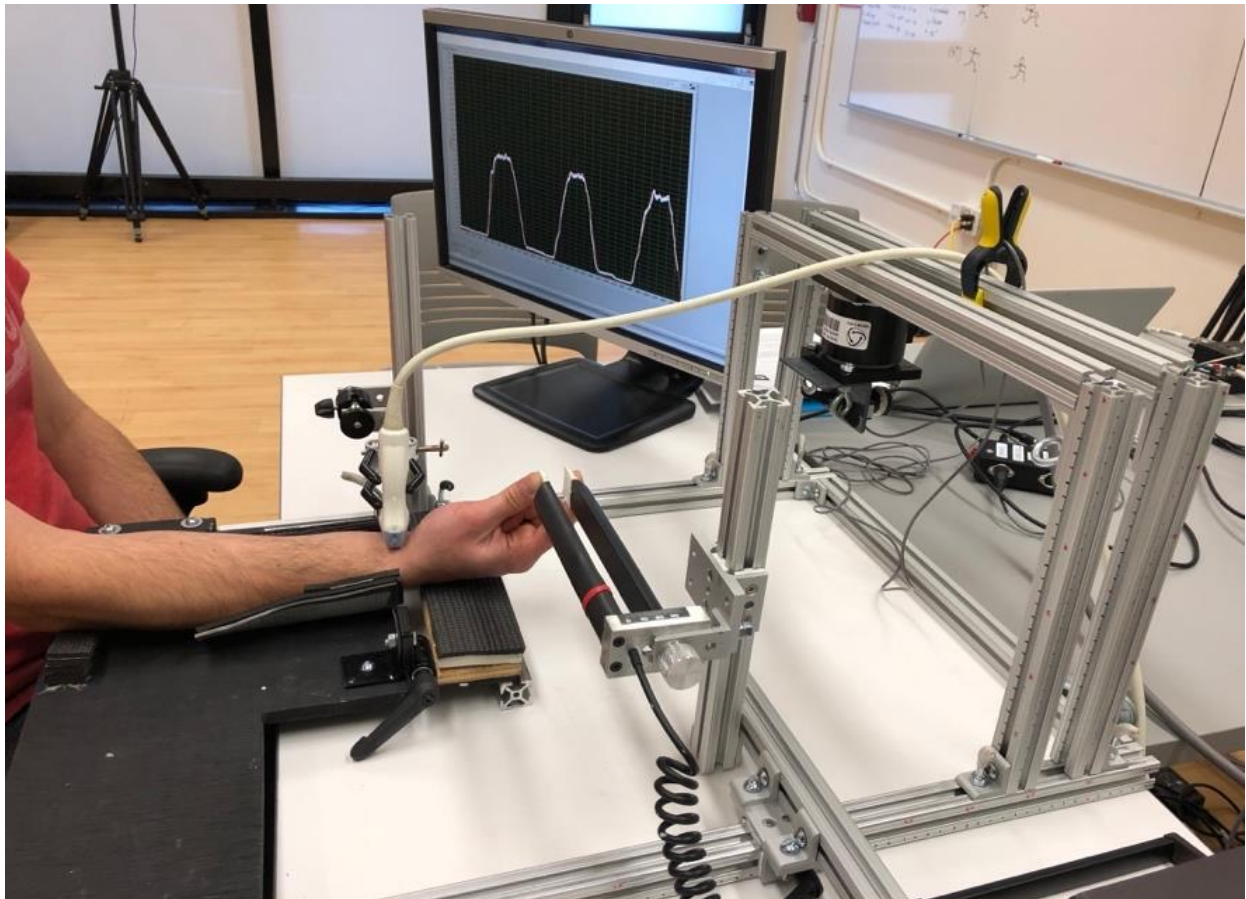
Custom built testing apparatus supporting the right distal upper limb of the participant. Adjustable features allowed the grip dynamometer to translate in 3 axes (superior-inferior, proximal-distal, medial-lateral) and rotate about 1 axis (medial-lateral) to enable interaction with the participant. The ultrasound probe was positioned at the base of the wrist using a three-prong clamp attached to a locking ball-and-socket joint. *Note: Image belongs to the author.*
